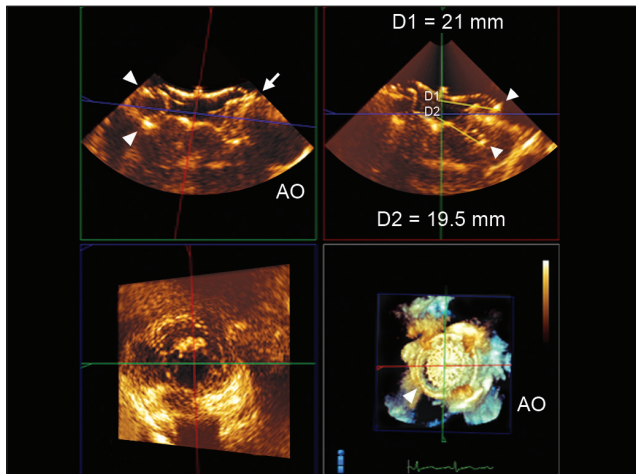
Live/real time three-dimensional transesophageal echocardiographic demonstration of encroachment of the aorta by the atrial septal defect (ASD) closure device. Multiplanar rendering mode: Upper panels. Top arrowheads point to the left atrial disc, lower arrowheads to the right atrial disc. D1 represents the measurement of the radius of the left atrial disc from the middle of the central marker band to the outer edge of the disc. D2 represents the measurement of the radius of the right atrial disc from the middle of the end screw to the outer edge of the disc. The arrow in the top right panel points to the area of contact of the left atrial disc with the aorta (AO). Lower panels. Arrowhead in the right lower panel points to the left atrial disc covering the ASD. Reproduced with permission from Bhaya M, Mutluer FO, Mahan III EF, et al. Incremental utility of live/real time three-dimensional transesophageal echocardiography in percutaneous closure of ASD. *Echocardiography* 2013;30:345-53
